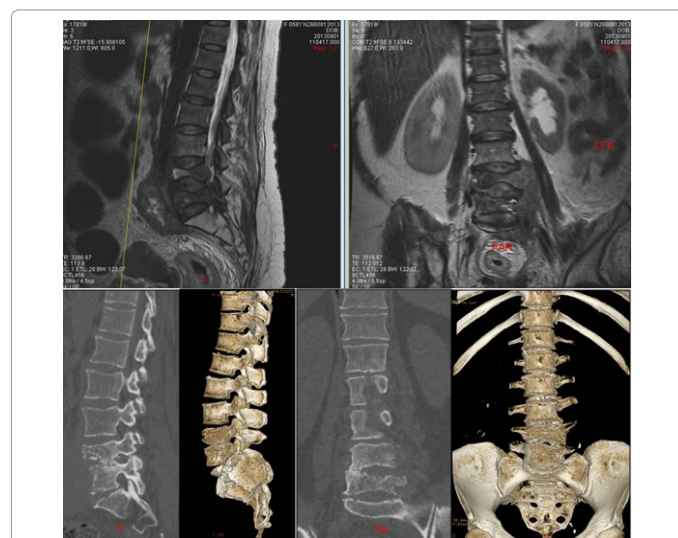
Simple MRI. Sagittal and Coronal views. Infiltrative process involving L4 and L5 vertebrae which are collapsed in 70-80%. The infiltration extends as a 66x35mm prevertebral tumor with soft tissue intensity and heterogenous aspect that surrounds great abdominal vessels and left ureter causing left hydronephrosis. Multiple hyperintense punctate lesions in both iliac crests, of lytical aspect. These images suggest tumoral infiltration, probably metastatic. CT-guided biopsy reported keratinizing squamous cell carcinoma metastasis.
